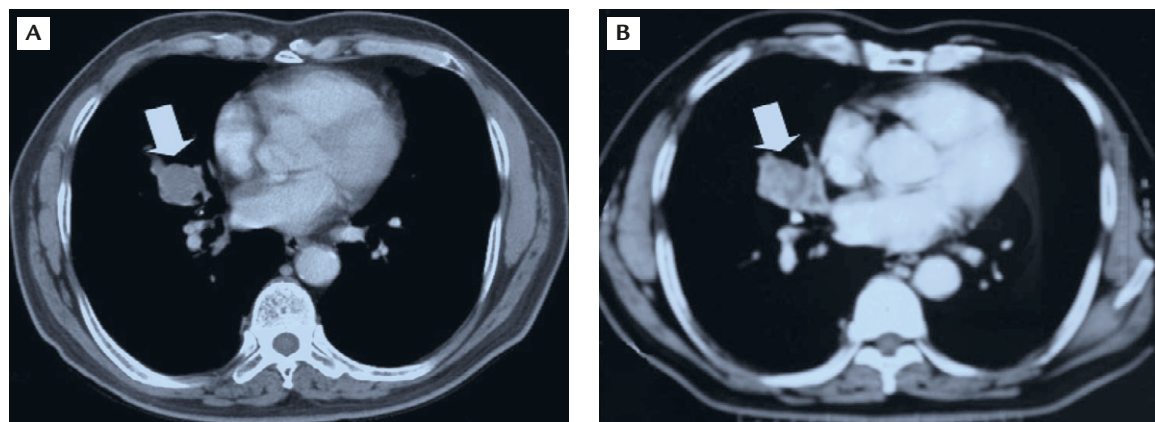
Chest computed tomography (CT) taken during treatment. (A) Chest CT taken on November 11th, 2008. (B) Chest CT on December 18th, 2008. (C) Chest CT on February 19th, 2009. (B) had no significant difference in mass size compared with (A). (C) showed slightly increased extent of cancer compared with (B).
